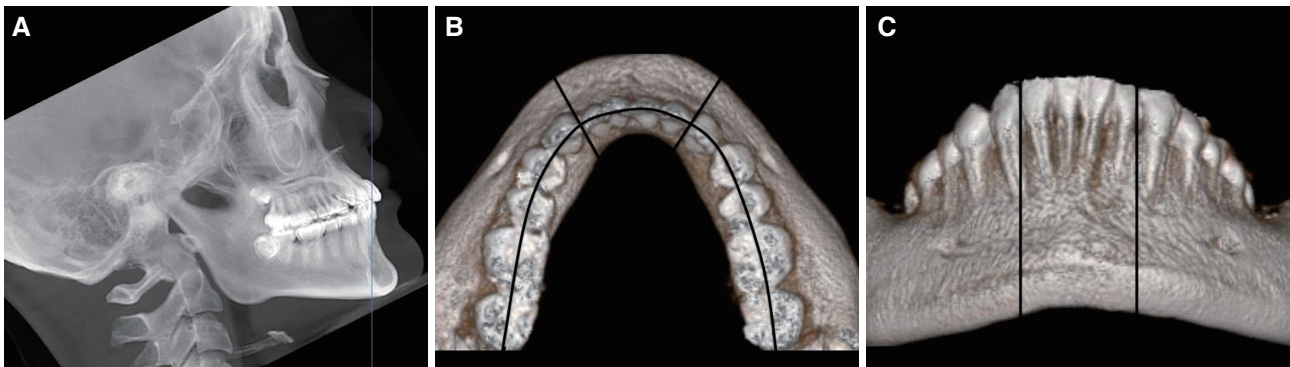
Measuring volume of mandibular symphysis. (A) CT image was re-oriented to make the axis of the mandibular central incisor perpendicular to the horizontal plane, (B) Symphysis was sectioned in the direction that was vertical to the re-oriented horizontal plane and to the mandibular dental arch and passing by the distal side of lateral incisors, (C) Frontal view.
